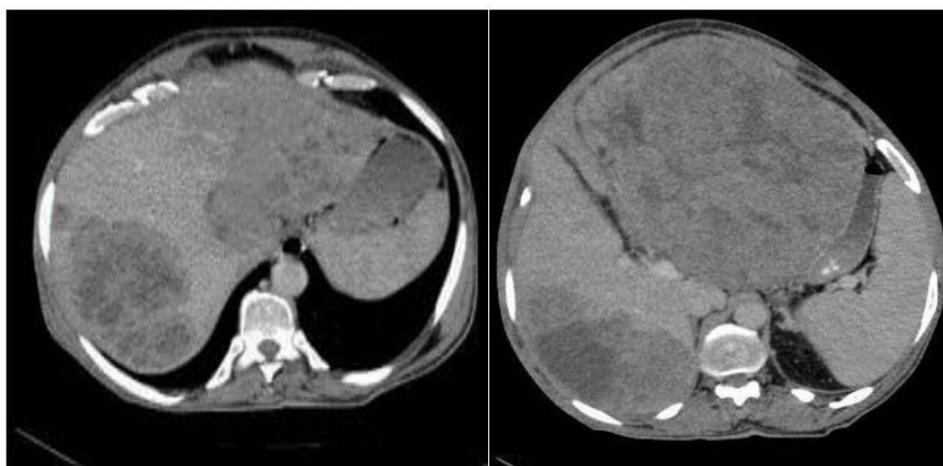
TAP CT: axial slice showing a large hepatic tumor process of the left liver with synchronous segment VI and VII tumor lesions
